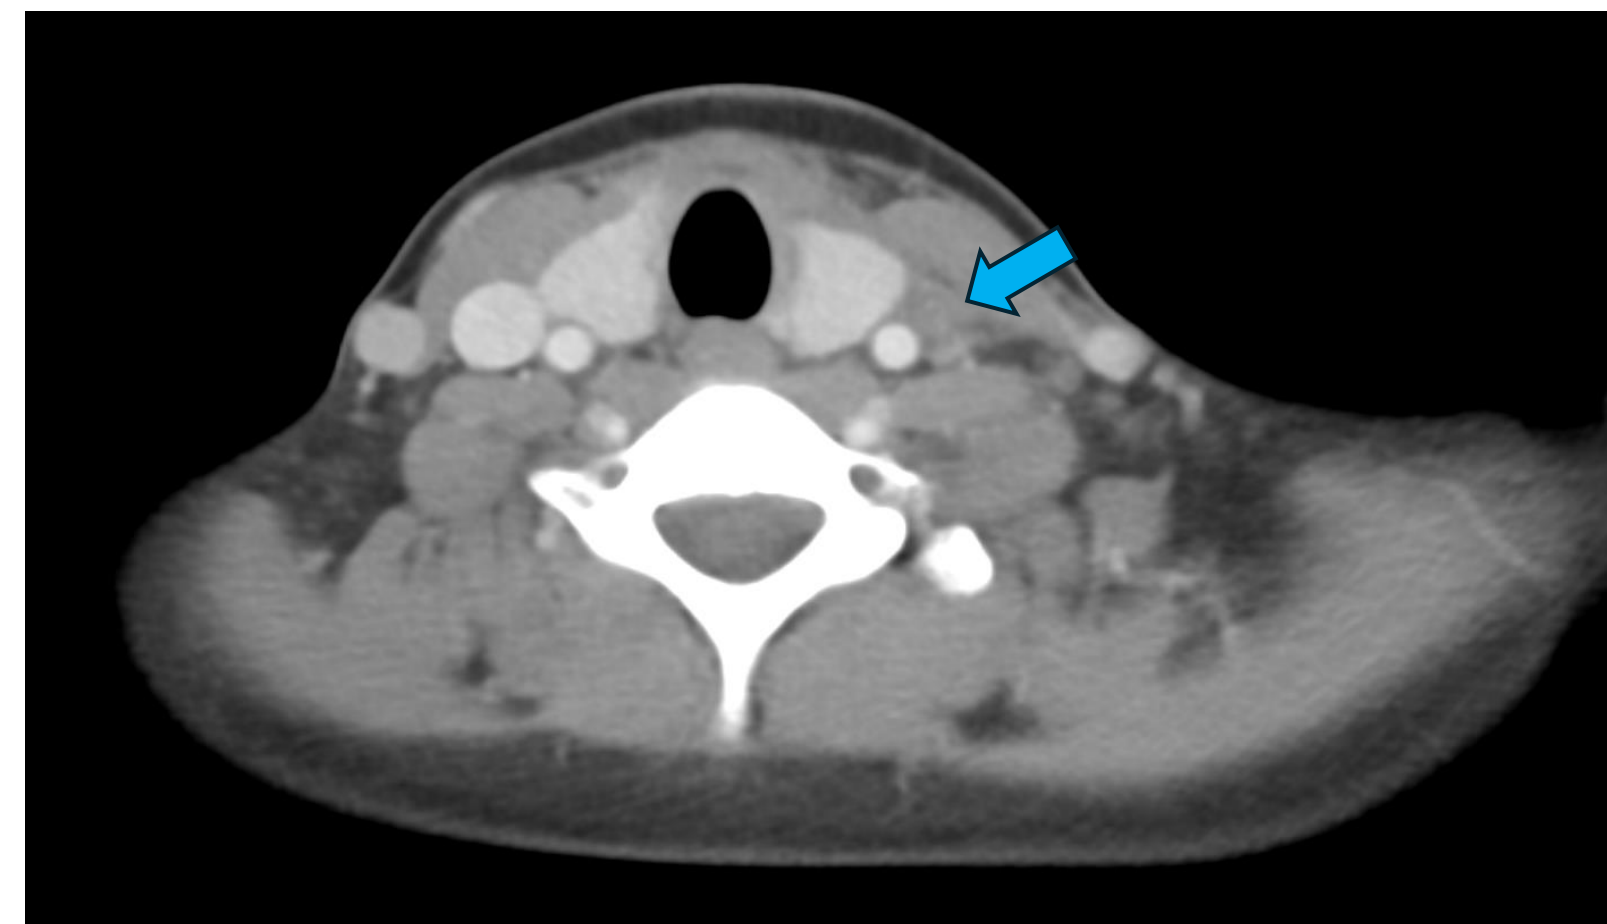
Axial view contrast-enhanced CT neck at the level of the thyroid gland
